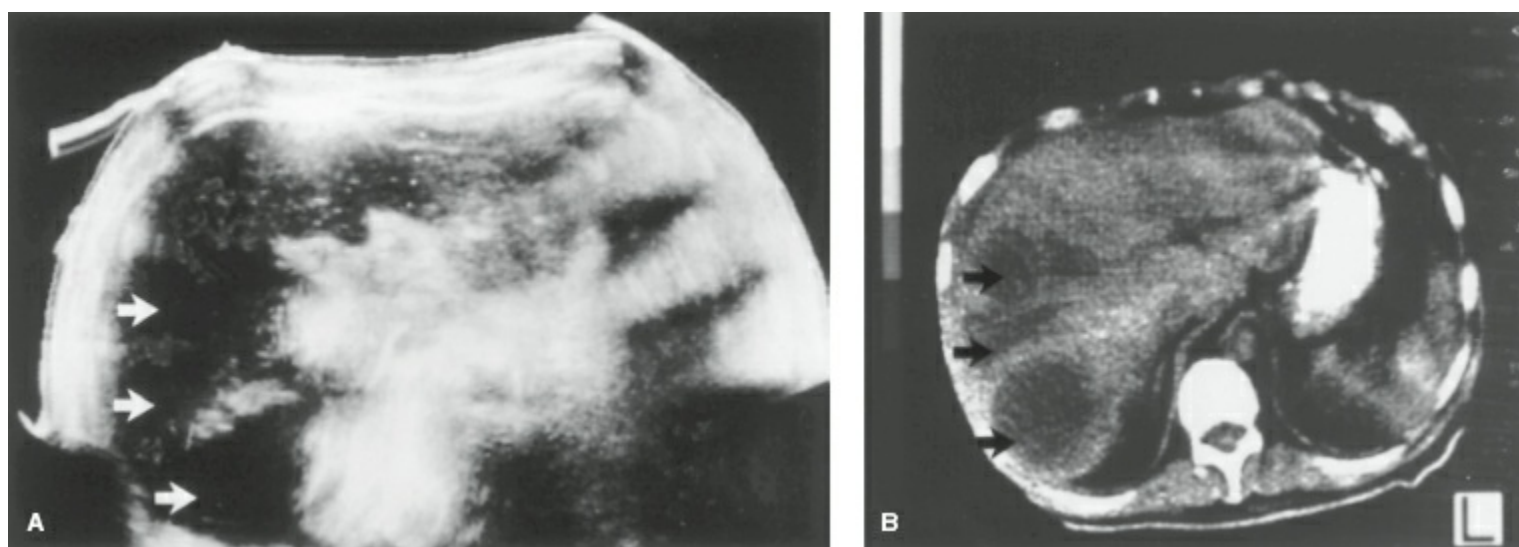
Sonogram (A) and computed tomogram (B) in a patient with multiple amebic abscesses (arrows).
